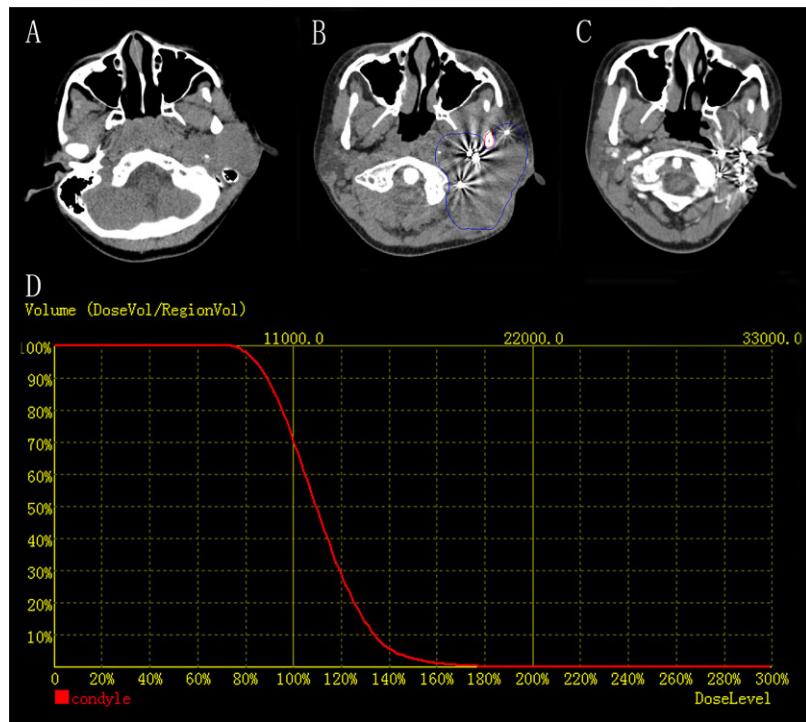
(A) CT image showing a T4 parotid carcinoma. The patient was treated with iodine-125 seed interstitial brachytherapy as a sole modality at the age of 8. (B) The condyle (the red line) of the affected side was delineated as the organ at risk. (C) The CT image after 112.1 months showed no sign of tumor recurrence. (D) Dose–volume histogram of quality verification in the brachytherapy treatment planning system showed the D90 of the condyle was 9785.8 cGy
